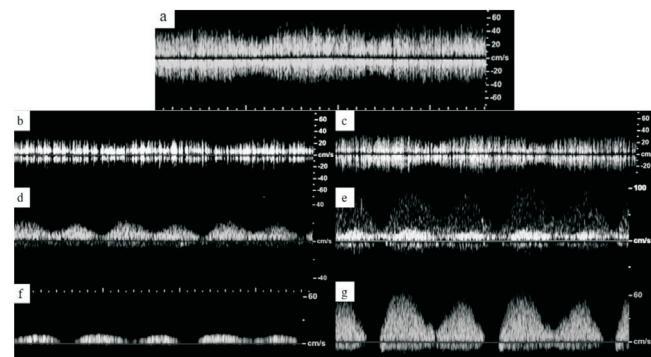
(a) Artificial cerebral blood flow dopplergrams in the conditionally healthy blood vessels; b(b) proximal artificial cerebral blood flow dopplergrams in 25% vasospasm; (c) distal artificial cerebral blood flow dopplergrams in 25% vasospasm; b(d) proximal artificial cerebral blood flow dopplergrams in 50% vasospasm; (e) distal artificial cerebral blood flow dopplergrams in 50% vasospasm; (f) proximal artificial cerebral blood flow dopplergrams in 75% vasospasm; (g) distal artificial cerebral blood flow dopplergrams in 75% vasospasm.
